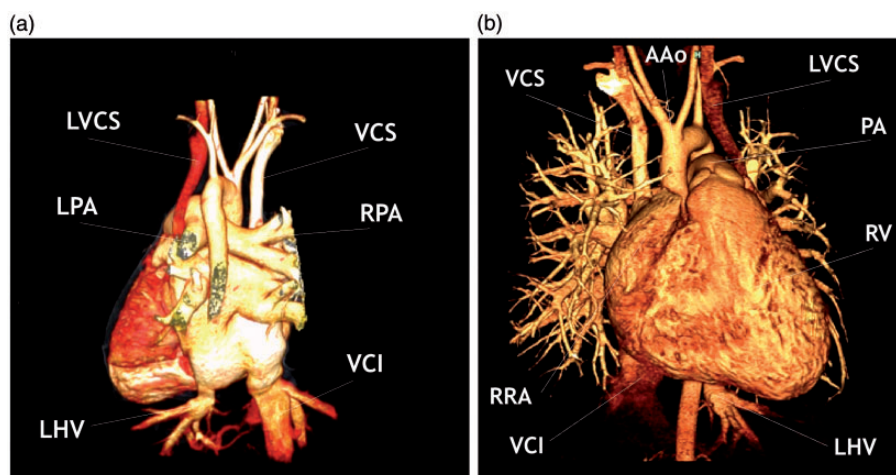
Multislice computed tomography with contrast: (a) rear view and (b) front view of the heart, showing the additional left superior vena cava (LSVC) flowing into the left atrium. AAo: ascending aorta; IVC: inferior vena cava; LHV: left hepatic vein; LPA: left pulmonary artery; PA: pulmonary artery; RAA: right atrial appendage; RPA: right pulmonary artery; RV: right ventricle; SVC: superior vena cava.
